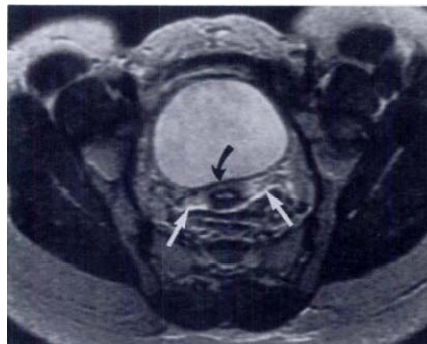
Normal cervix and parametria. Axial oblique T2-weighted MR image obtained through the cervix (black arrow) demonstrates triangular moderate signal intensity of normal parametria (white arrows) (*Quoted from Olson et al., 1992*).
